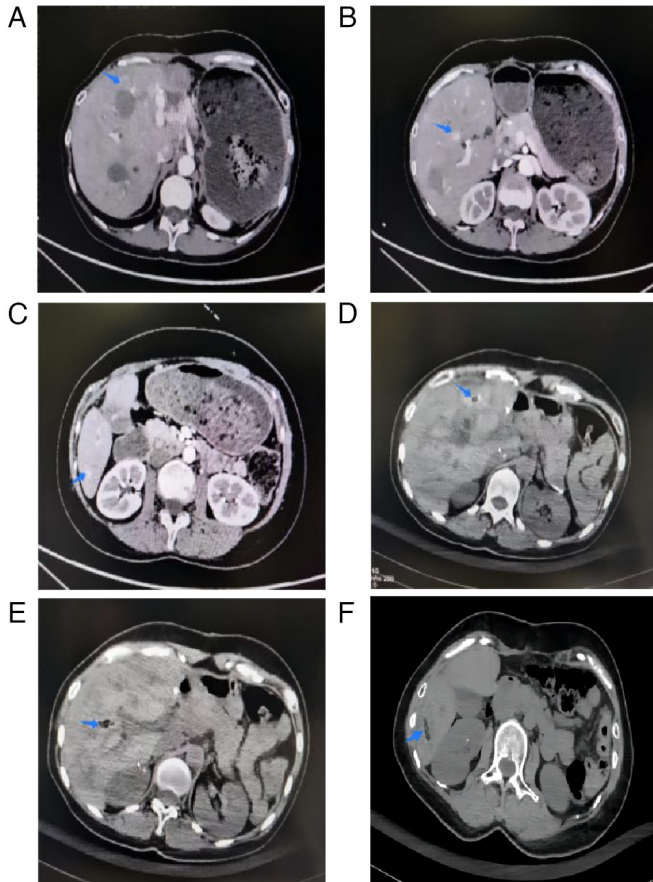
CT acquired at postoperative month 18. CT images (A-C) before and (D-F) after microwave ablation of residual liver metastases. CT, computed tomography (arrows indicate the liver metastasis lesion location).
